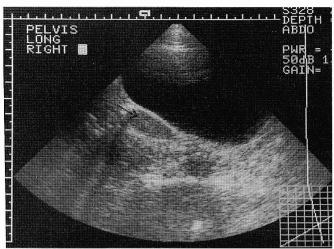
An ultrasound scan of an undescended right testis.
